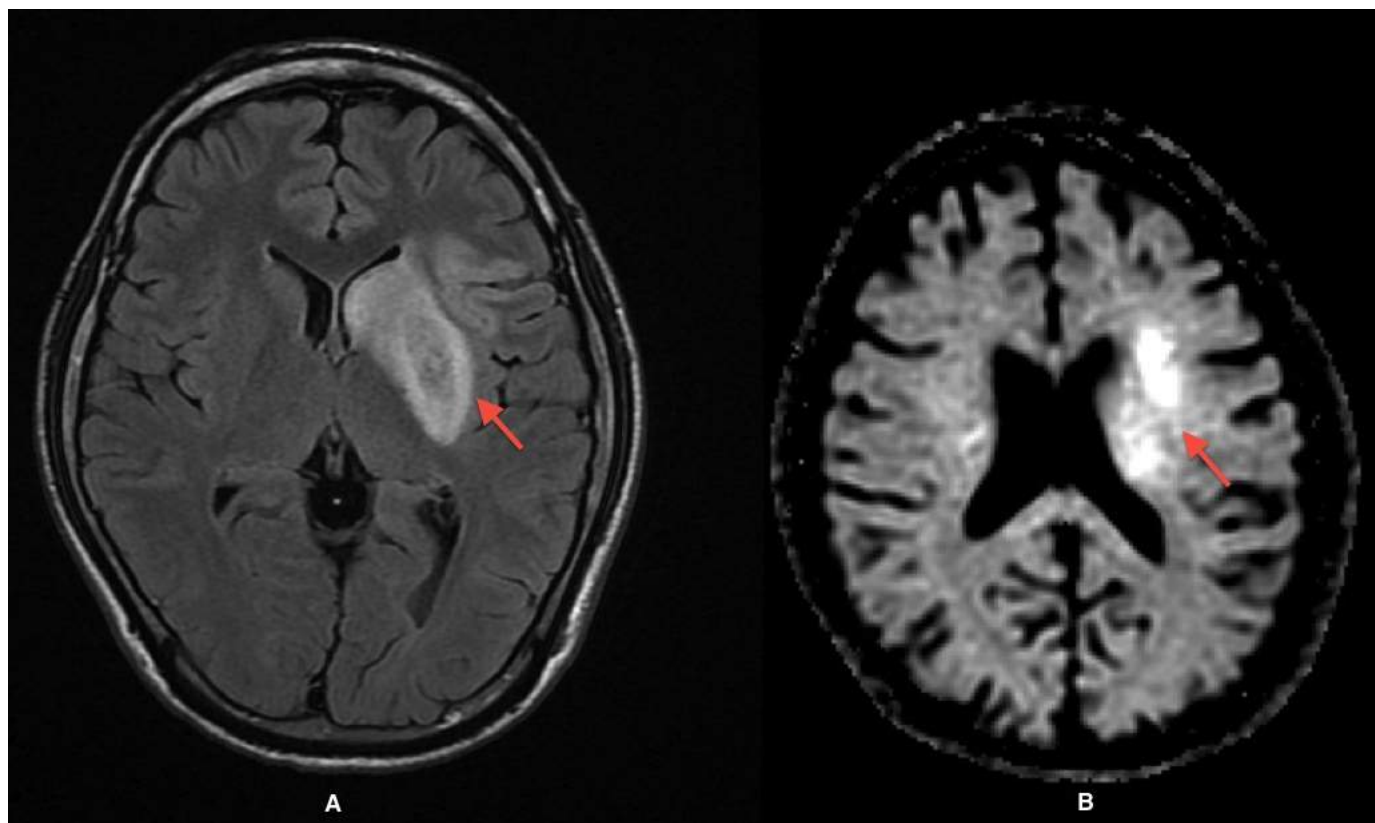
(A) T1-weighted and (B) diffusion weighted magnetic resonance image of the brain showing an evolving infarct (arrows) involving the left-sided deep basal ganglia, thalamus and cerebral cortex.
